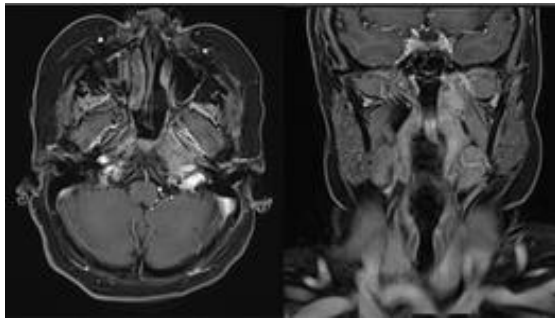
The axial and coronal MRI of the patient after receiving treatment.
